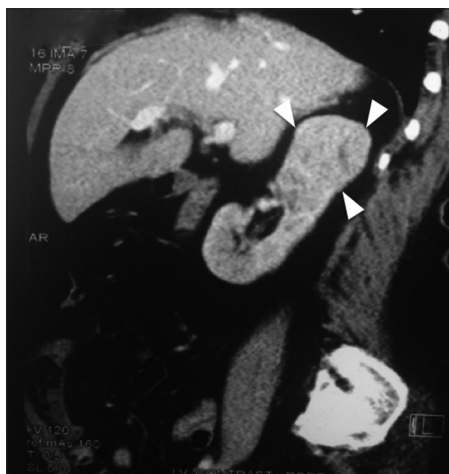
Contrast enhanced computed tomography image of the abdomen: 5.5 cm × 4.4 cm sized well encapsulated inhomogeneous mass (arrow heads) with central areas of necrosis in the upper pole of right kidney
